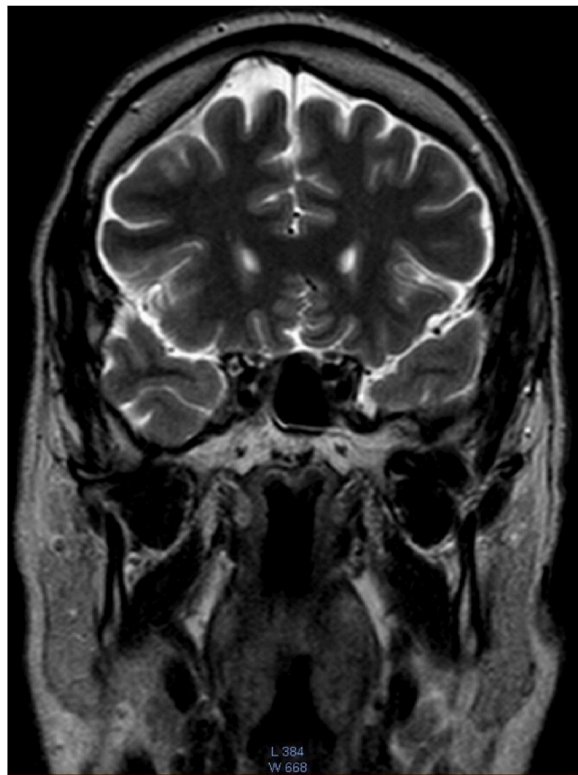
7-year-follow-up MRI revealed the absence of recurrence.
